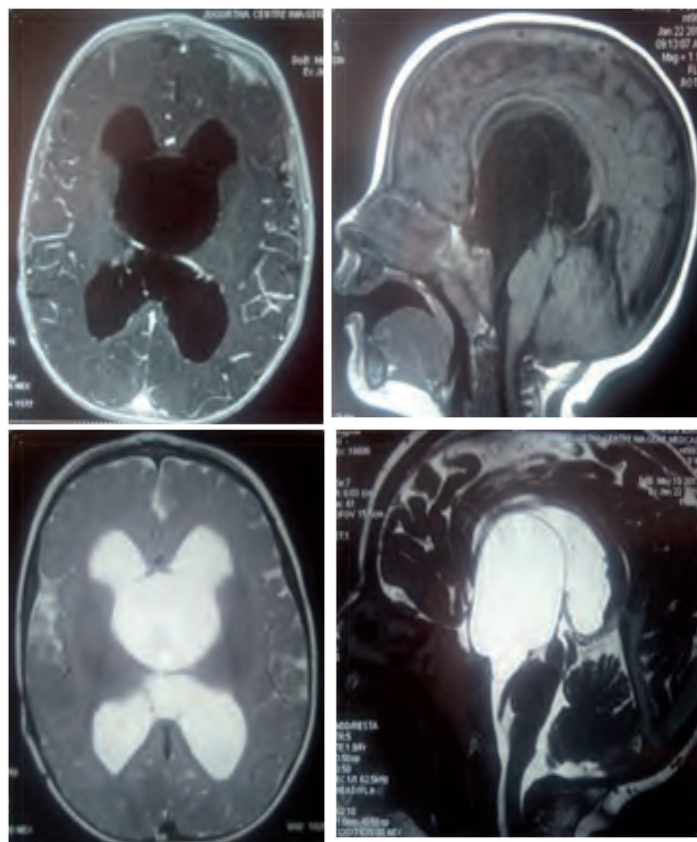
A 3-year-old male presented with worsening headaches and bobble head doll syndrome. MRI axial, sagittal (T1, T2) images show a suprasellar arachnoid cyst projecting into the third ventricle with hydrocephalus.
